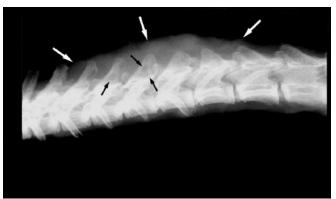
Lateral radiograph of the spine from T6 through L1. A soft tissue swelling is seen dorsal to the spine, extending from T8 to T13 (white arrows). Lucencies in the spinous processes of T9 and T10 (black arrows) represent osteolysis.
